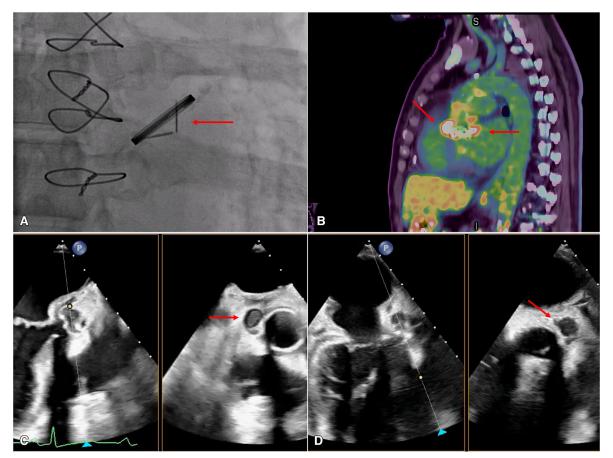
Preoperative evaluations. A, Valve fluoroscopy showed 1 stuck tilting disc (*red arrow*). B, Positron-emission tomography cardiac imaging identified 2 separate annular abcesses (*red arrows*) but ruled out distal hemiarch graft involvement. C and D, Intraoperative transesophageal echocardiography; images showing abscess formations around right coronary artery (C) (*red arrow*) and left main coronary artery (D) (*red arrow*).
